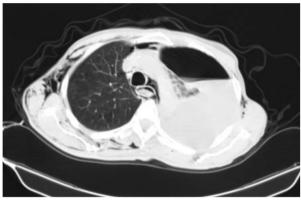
Axial image of non-contrast chest CT revealed a large leftsided hydropneumothorax, characterized by a clear air-fluid level and near-complete collapse of the left lung, with associated rightward mediastinal shift
